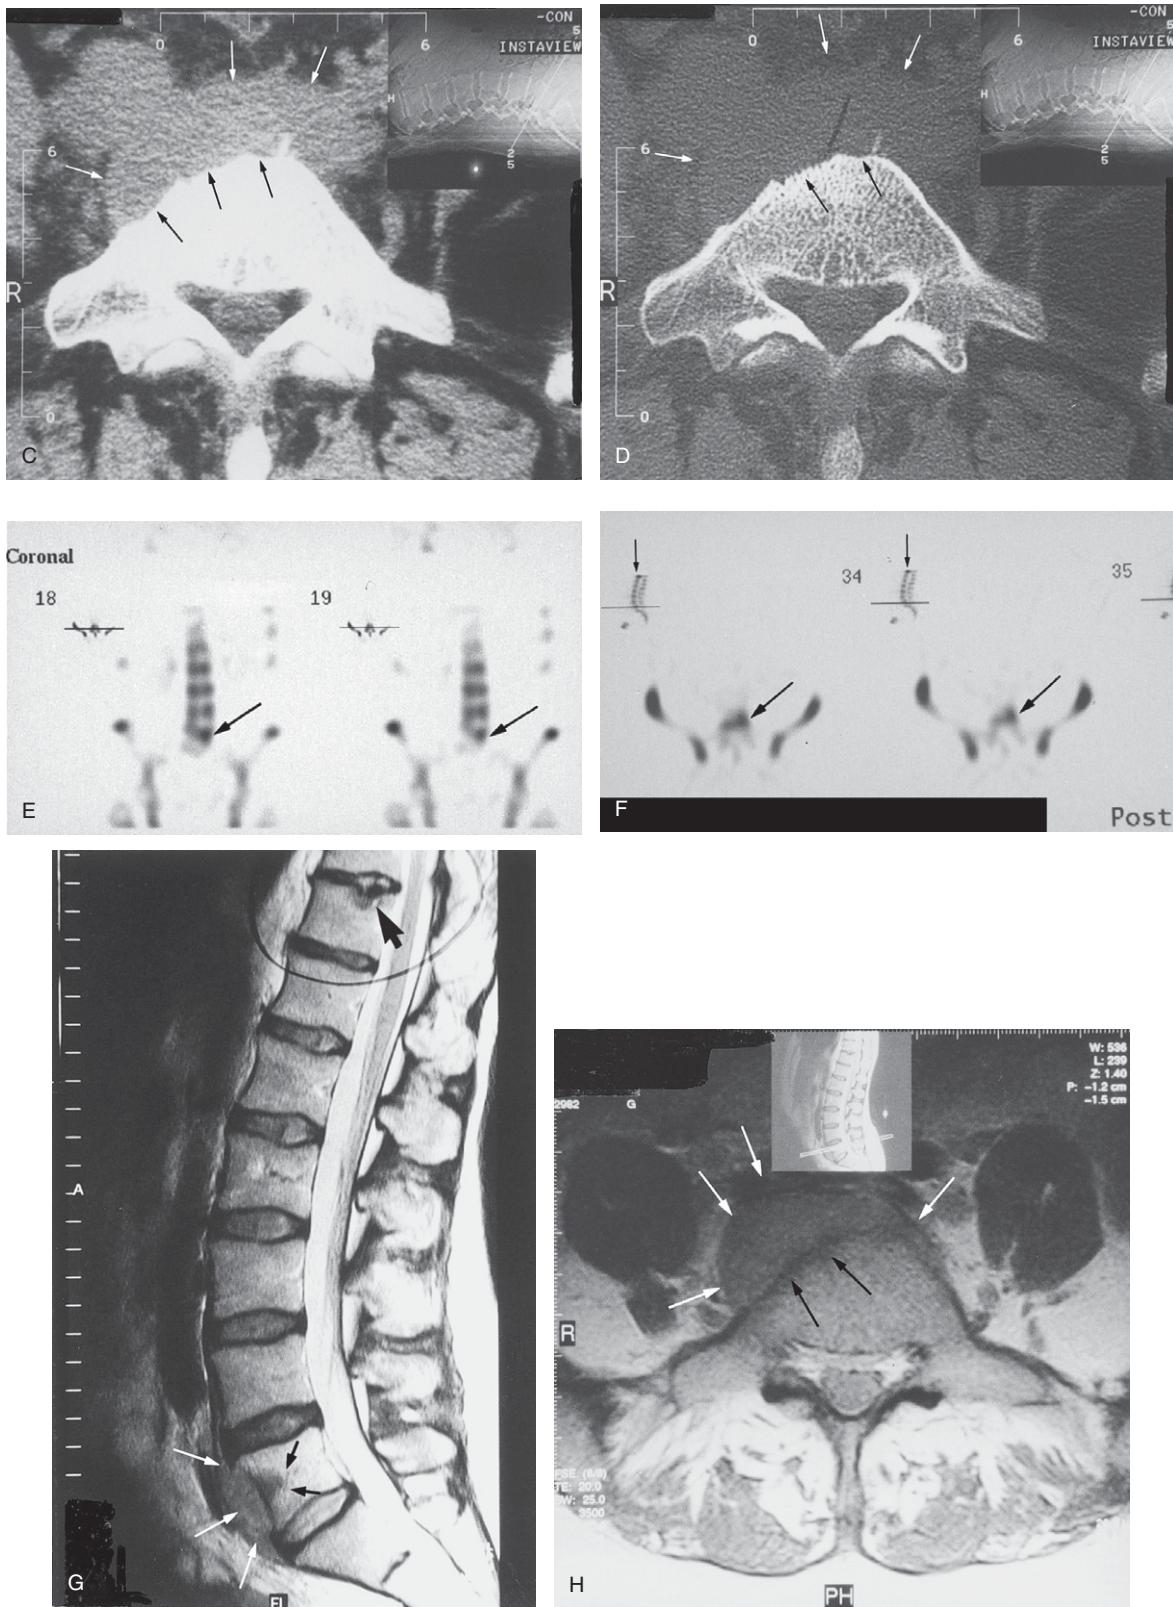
Cont'd (C) A CT axial soft tissue image through the upper one-third of the L5 vertebral body. Note the pre-vertebral soft tissue density, with similar density to muscle tissue, anterior to the vertebral body margin (white arrows) and the bony erosion along the anterior cortical margin of the L5 body (black arrows). R = right side of patient. (D) CT axial bone window image showing the features mentioned in (C). R = right side of patient. (E) Bone scan coronal images showing increased uptake in the L5 vertebral body (arrow). (F) Bone scan horizontal image through the L5 body showing the increased uptake in the L5 vertebral body (arrows) and what appears to be a hotspot in the T11 body, although this is at the very edge of the SPECT scanning and therefore could be due to possible 'edge effect' (short black arrows). (G) Lumbarosacral spine MRI sagittal T2-weighted image showing 'significant soft tissue mass in the subligamentous location' anterior to the L5 vertebral body (white arrows) with some post-contrast enhancement within the L5 vertebral body consistent with inflammatory response related to this erosive process (black arrows). Note the Schmorl's node in the upper endplate of the T11 vertebra. (H) MRI axial T1-weighted image through the upper one-third of the L5 vertebral body, showing the subligamentous soft tissue mass (white arrows) with erosion of the anterior aspect of the right half of the vertebral body (black arrows). R = right side of patient.
